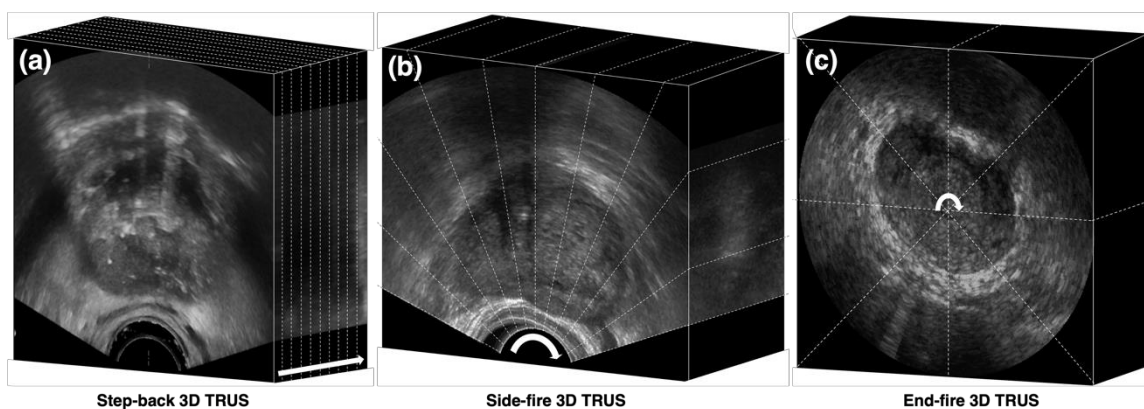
Example (a) axially reconstructed step-back, (b) sagittally reconstructed side-fire, and (c) end-fire three-dimensional transrectal ultrasound images. The dotted lines in each image represent the original ultrasound acquisition planes that compose the 3D image. Arrows represent the direction of transducer motion during 3D acquisition.
